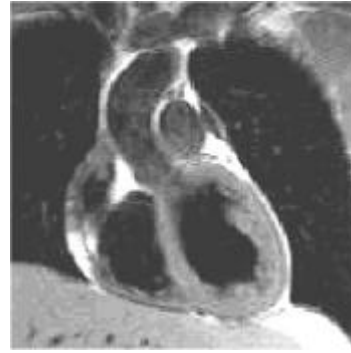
Coronal view of the unsegmented MRI heart model.
